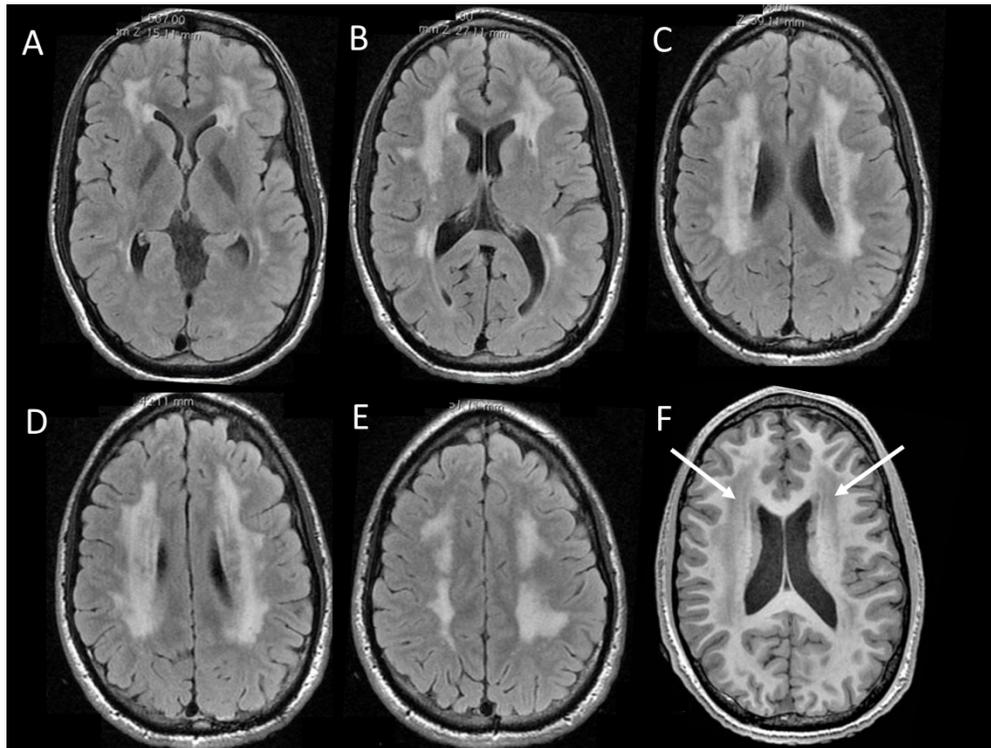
Brain MRI characteristics. MRI in Patient 1 at the age of 20 years showed diffuse periventricular white matter abnormalities with hyperintensities on FLAIR sequences (A-B-C-D-E) and hypointensities (arrows) on T1-weighted sequences.
